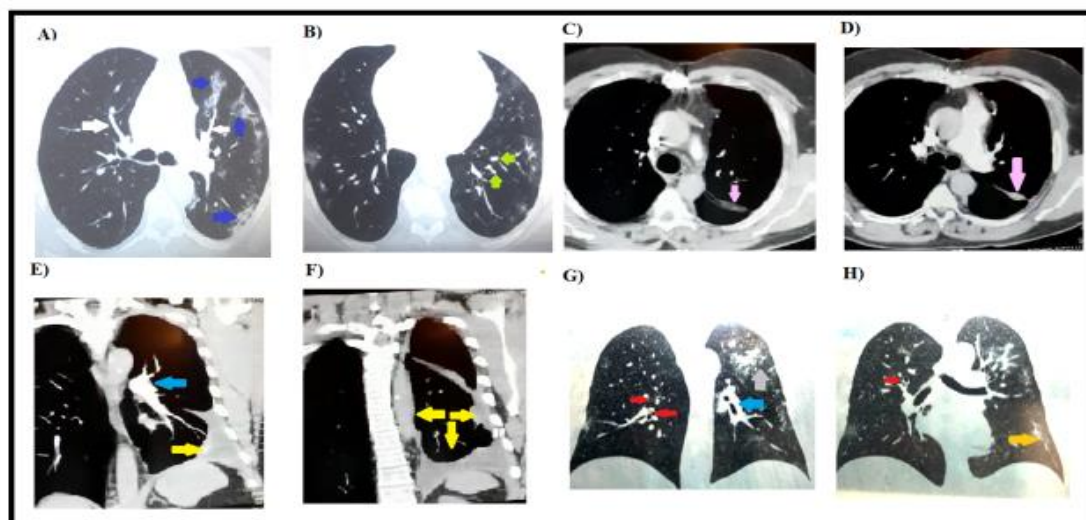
Computerized tomography (CT) angiography for lung of COVID-19 patients, axial image shows areas of consolidation with peripheral ground glass lesion (GGO) with broncovascular interstitial thickening (white arrow), multifocal consolidation (dark blue arrow) (A) and multiple centrilobular nodules with tree in bud pattern opacities (green arrow) (B), Axial CT image shows presence of parenchymal bands (pink arrow) (C, D), Coronal image showing scleroderma (blue arrow) with diffuse reticular interstitial pattern and a plural effusion (yellow arrow) (E, F), and Coronal CT image shows GGO with air-bronchogram (red arrow), and consolidation lesion (grey arrow) (G), appearance of scleroderma interstitial lung disease (blue arrow) and subplural lines (orange arrow) (H).
